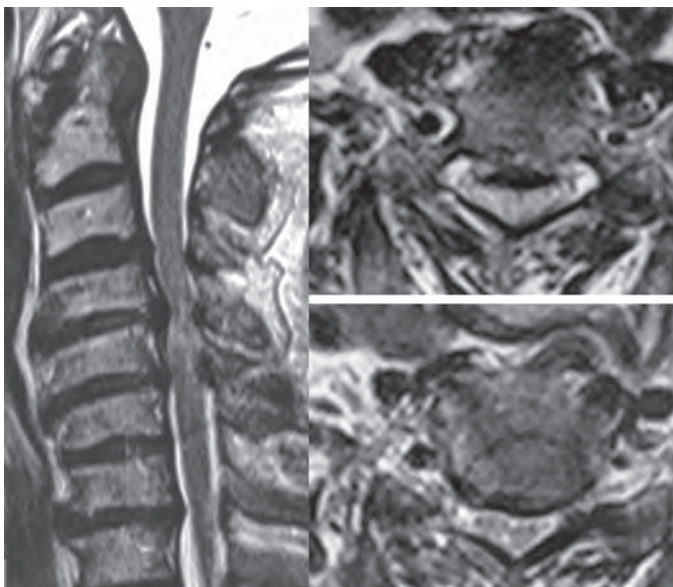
MRI cervical spine showing global cervical canal stenosis, anteriorly due to opacified posterior longitudinal ligament and osteophytes, and posteriorly due to ligamentum flavum hypertrophy along with signal changes in the cord in the compressed segment
